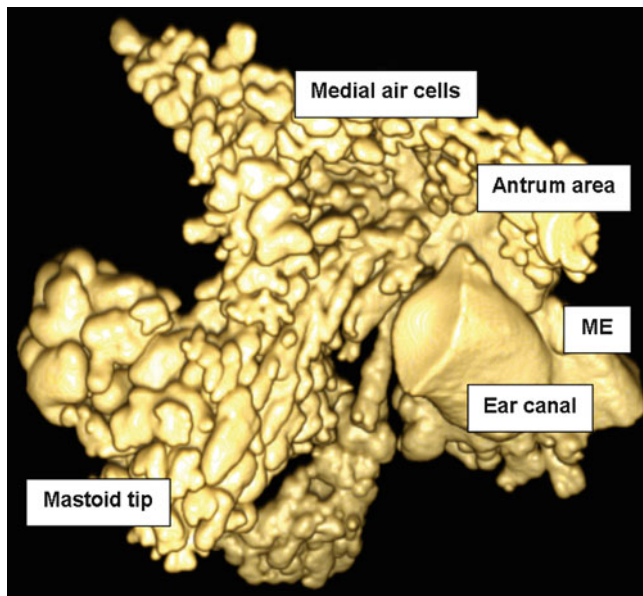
The normal mastoid with clusters of air cells emerging from the posterior part of the *ME*. The ear canal is seen at the *right side* in the *middle* of the image. The image is based on a 3D reconstruction of a high-resolution clinical CT scanning, where the surface compact bone has been made transparent (Courtesy of Olivier Cros)
